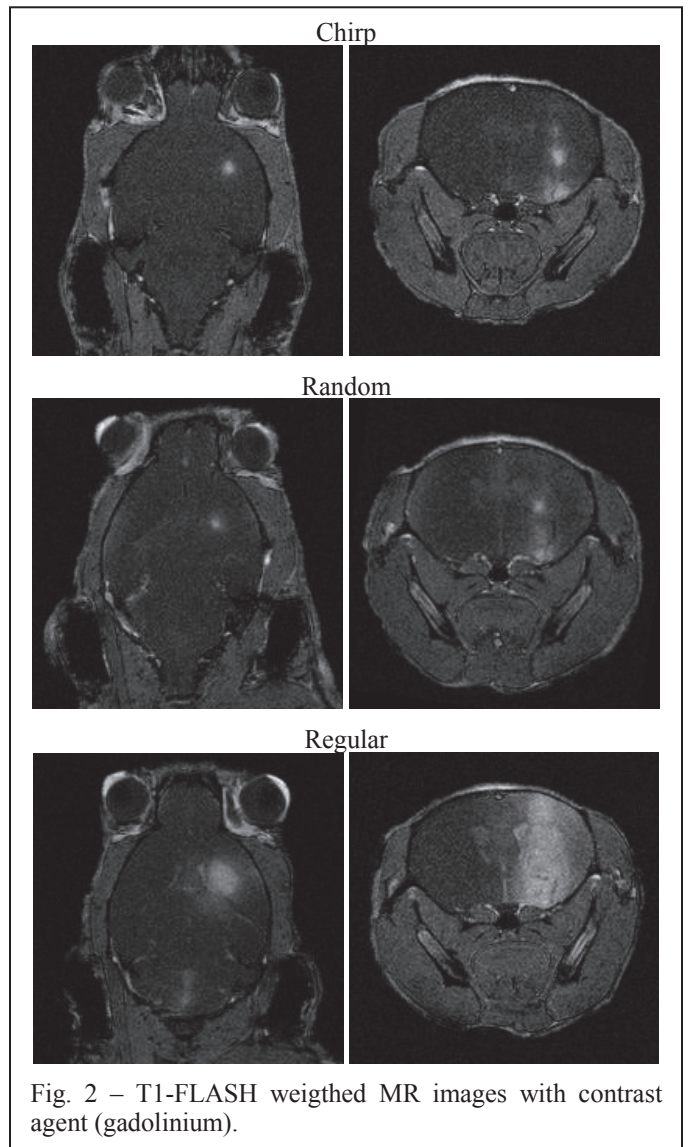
T1-FLASH weighed MR images with contrast agent (gadolinium).
